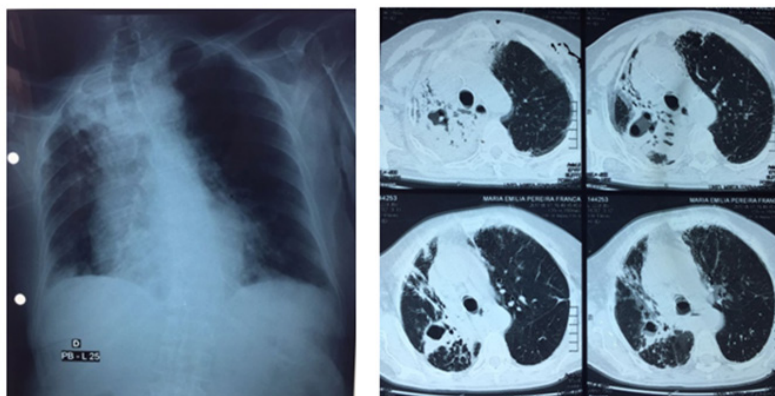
Thoracic radiography and computed tomography showing consolidation in the apical and posterior segments of the right upper lobe, with areas of extensive excavation; foci and sparse areas in the rest of this medium lobe, lingula and right lower lobe.
